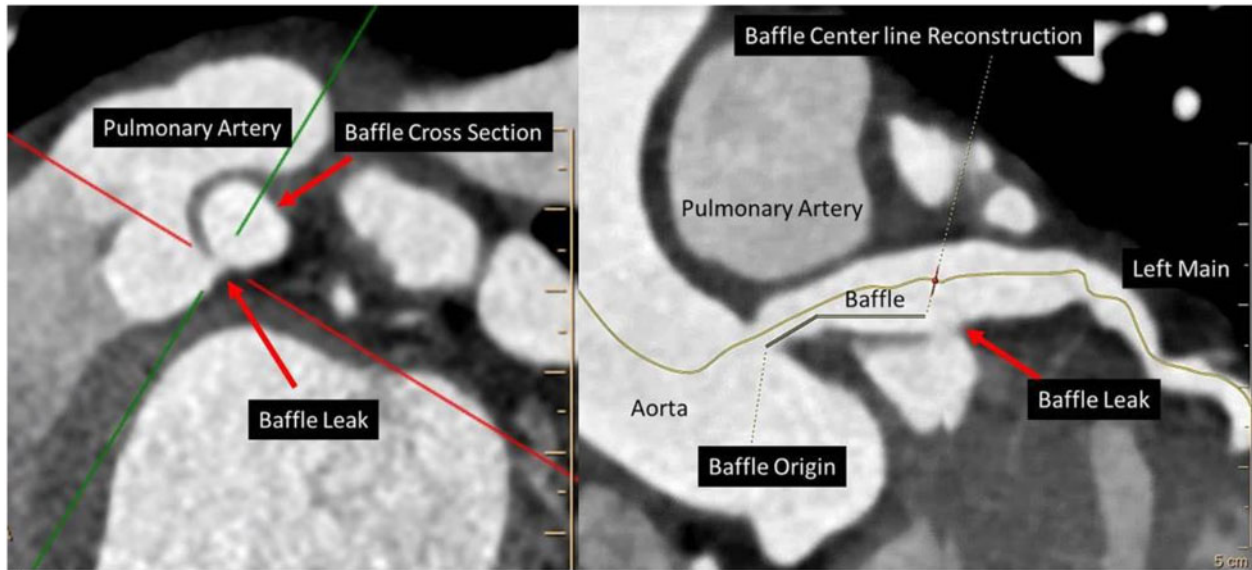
(A/B). A computed tomography coronary angiogram revealed a 6.5 mm × 2.4 mm leak present from the distal inferior Takeuchi baffle to the main pulmonary artery.
